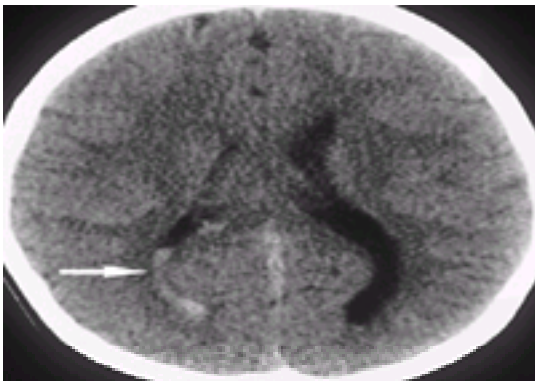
Intraventricular hemorrhage. This head computed tomography (CT) scan was performed on an 8-year-old girl who was involved in a sledding accident. She presented in coma. The *arrow* indicates hemorrhage in the right lateral ventricle. Note the layering of blood inferiorly in this supine patient. Other “cuts” of the CT showed areas of punctate hemorrhage consistent with diffuse axonal injury. The patient made an excellent recovery, with minimal neurologic deficits.
